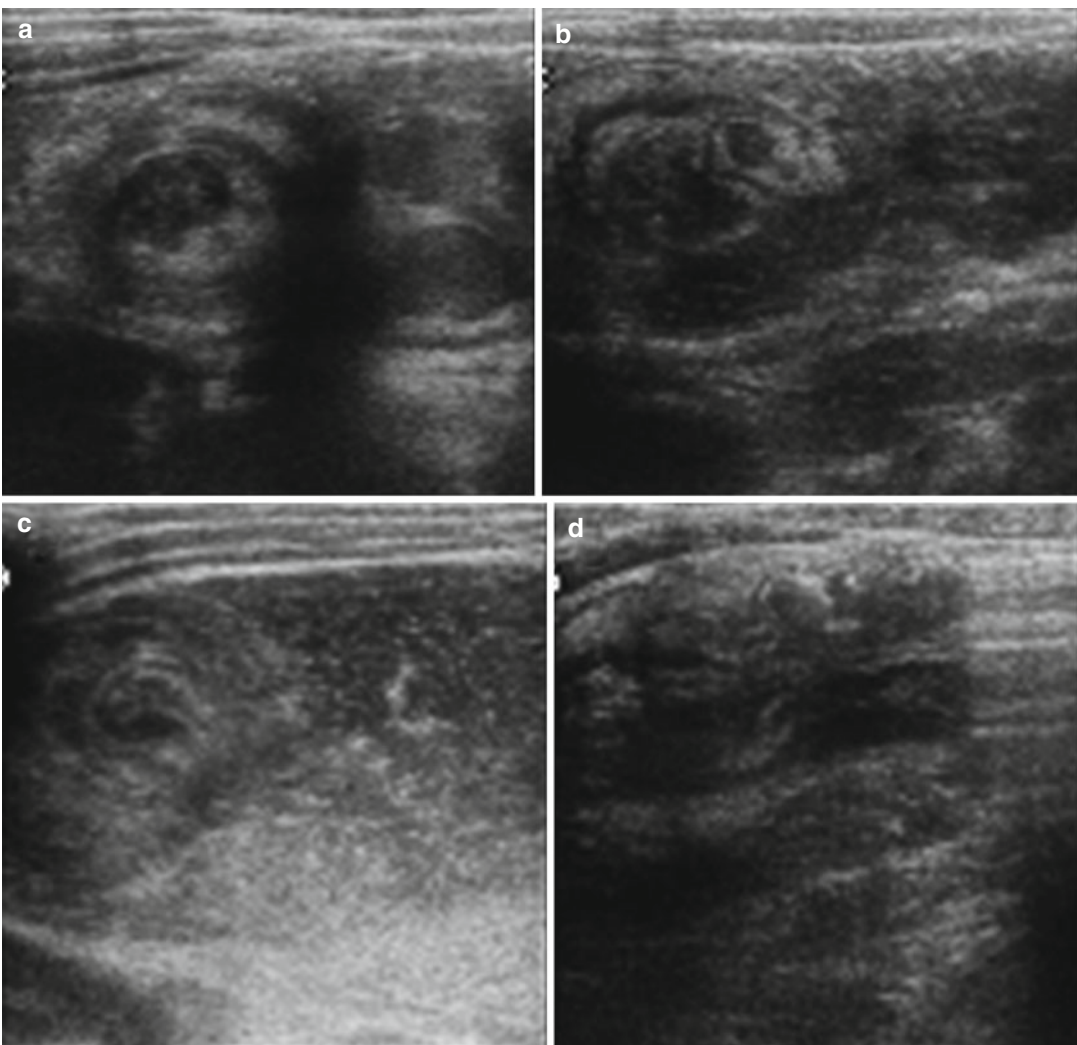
(a–j) Ultrasound axial and longitudinal scans in an infant with intestinal intussusception during the enema under ultrasound guidance. X-ray performed at the end of the procedure confirms the success of the procedure
